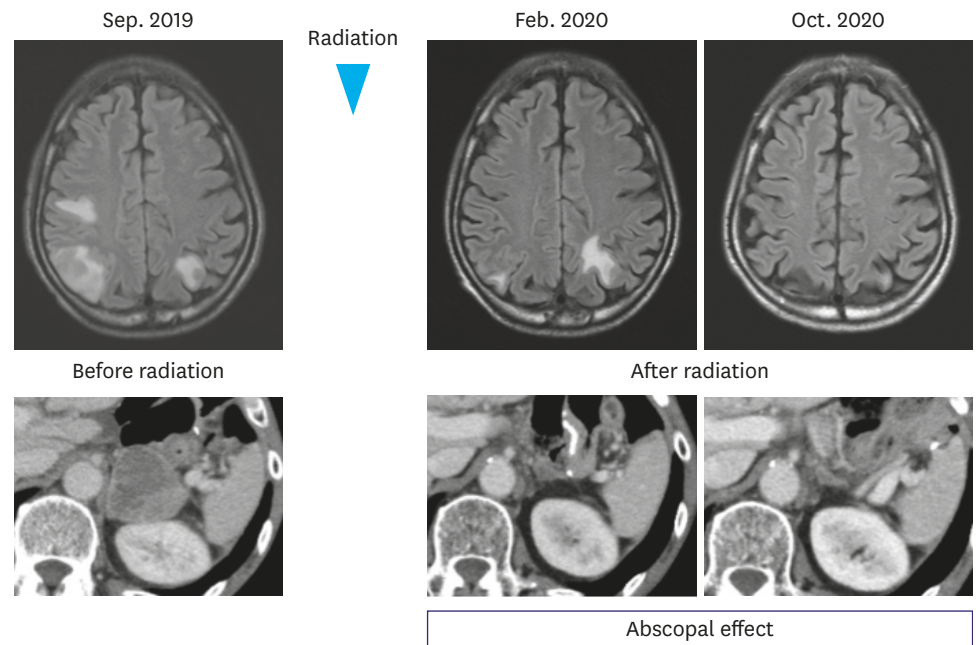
Time-course changes of the brain metastases (magnetic resonance imaging) and the abdominal lymph node metastasis (computed tomography) are shown.
